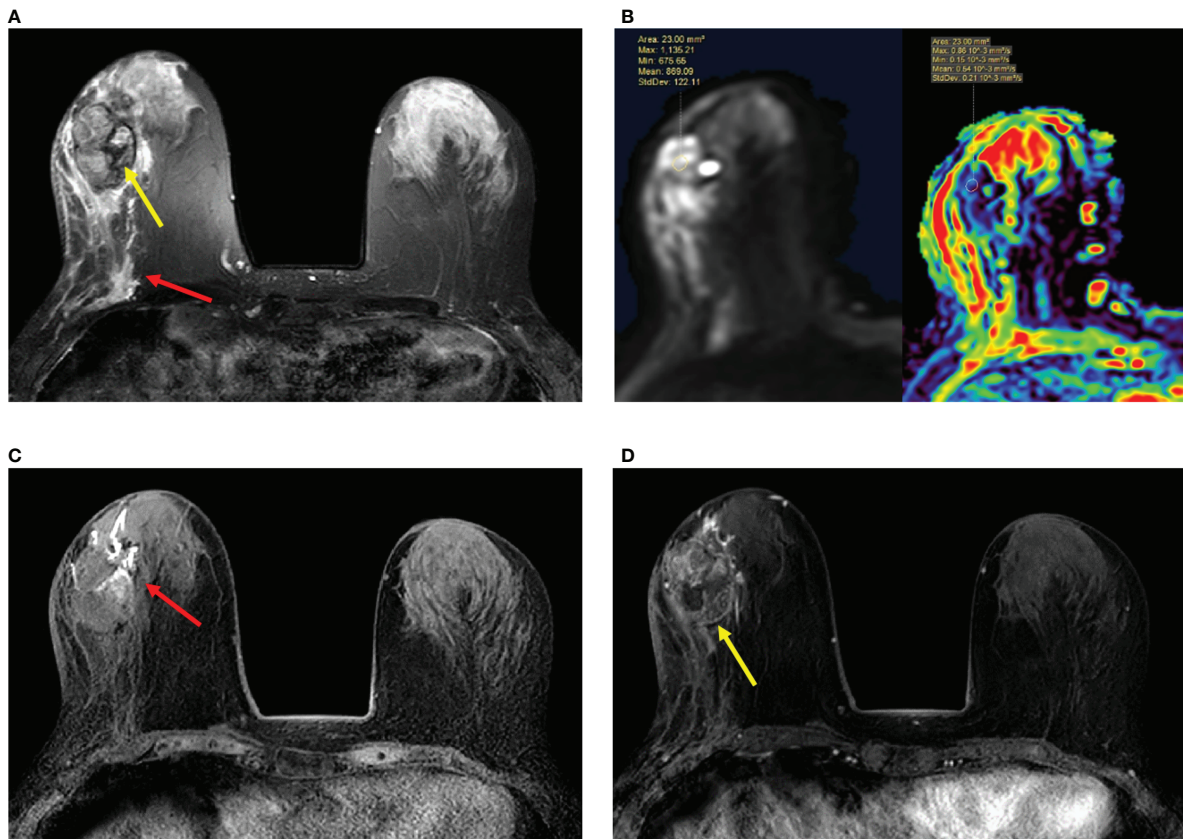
(A–D) Papillary ductal carcinoma *in situ* in a 72-year-old woman. (A) T2-weighted image showing a hypointensity signal mass lesion (yellow arrow) and a large edema signal behind the mass (red arrow) in the left breast. (B) Diffusion-weighted imaging showing a hyperintensity signal mass lesion and apparent diffusion coefficient map showing mean $ADC = 0.54 \times 10^{-3} \text{ mm}^2/\text{s}$. (C) Plain T1-weighted image showing duct dilatation (red arrow) in front of the mass. (D) Enhanced T1-weighted image showing the nonhomogeneous enhancement of an irregular-shaped mass with ill-defined margins (yellow arrow). Time-signal intensity curve manifests as a slow increase (initial phases) and a persistent type (delayed phases).
